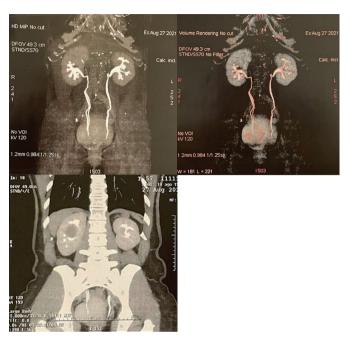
Abdominal magnetic resonance image of vascularized renal nodule in the right kidney.
